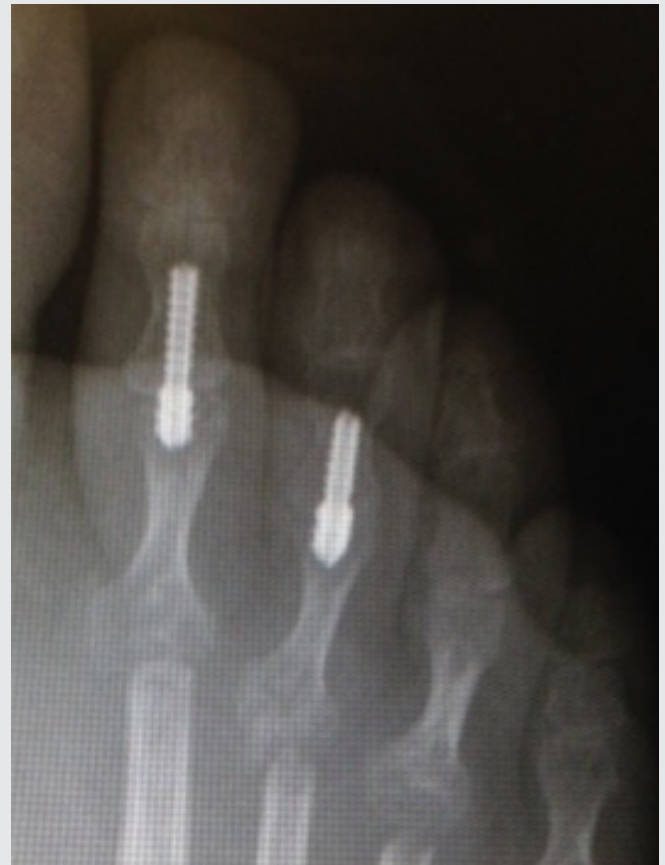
Anterior posterior radiograph showing completed digital fusion with the cannulated implant.
